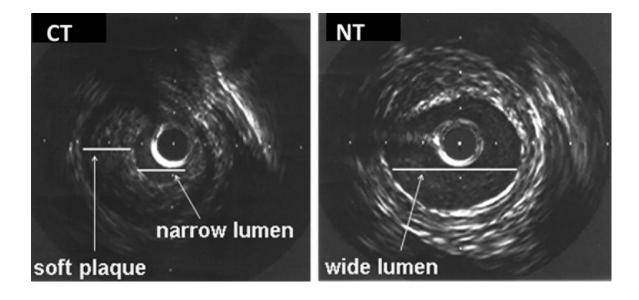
IVUS images of CT and NT SV grafts.
